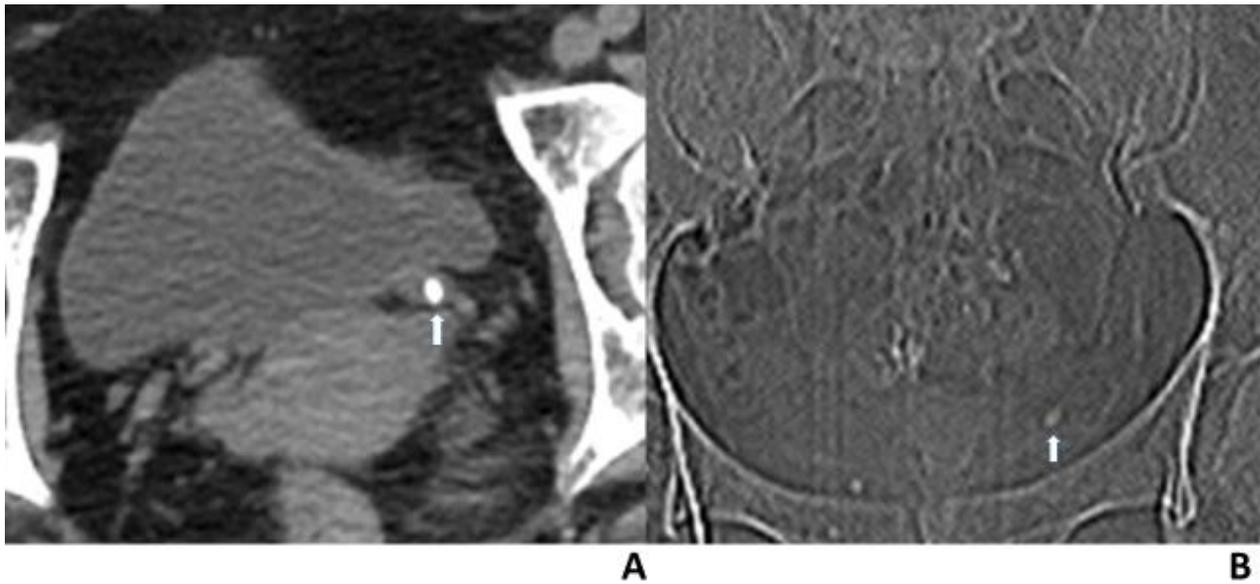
60-year-old woman with left ureteral stone. A, Axial CT scan shows a distal left ureteral stone (arrow) measuring 6 mm. B, CT scout radiograph shows left ureteral stone (arrow) distinct from the uterine calcifications.
